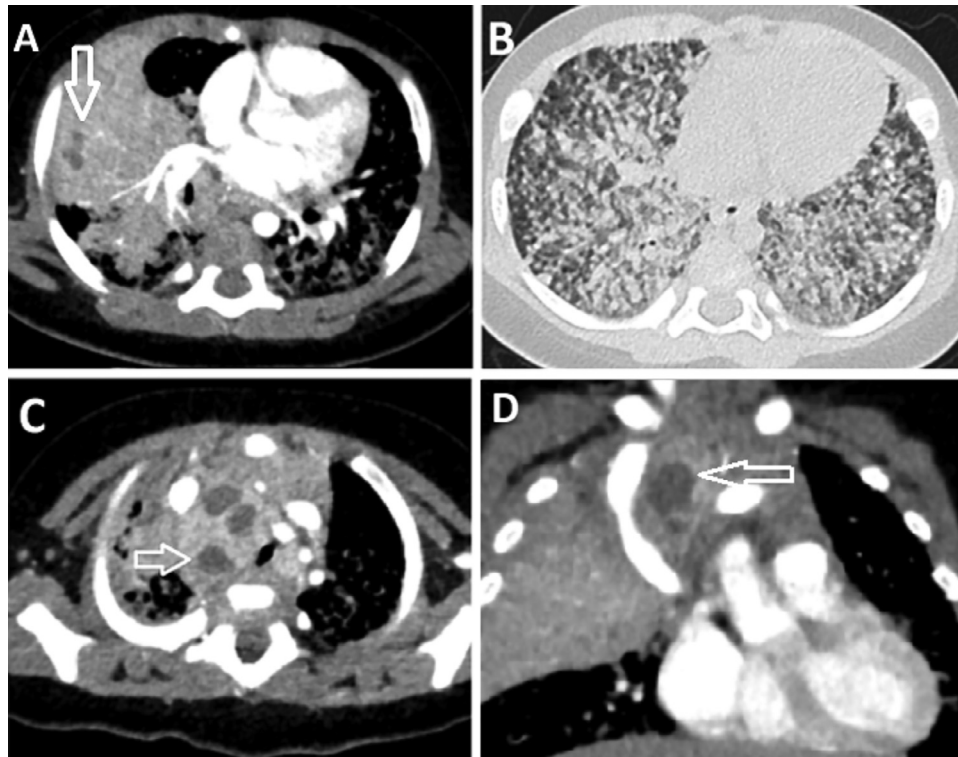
Chest CT scan with contrast (A, C and D) and in lung window (B). Chest computed tomography scan showed consolidation of the right upper lobe with central necrosis (A, arrow). Diffuse bilateral nodules were observed with random distribution, smaller than 3 mm in size (B). Multiple necrotic mediastinal lymphadenopathies were observed (C and D, arrows).
